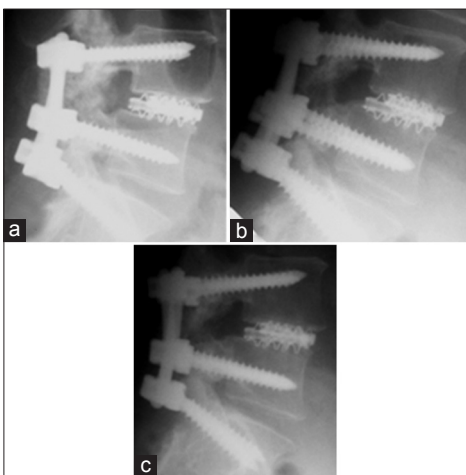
Follow-up X-ray images (a = 0, b = 3, c = 12 months, respectively) showing fusion (B-Twin system), but note lesser loss of disc space in comparison to autologus bone graft (compare with Figure 2)
